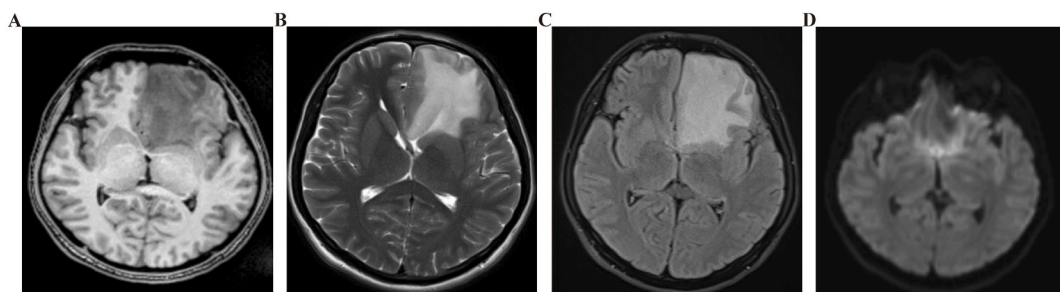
Pre-operative images of the intracranial granuloma. (A) T1-weighted MRI showed hypointense signal lesion in the left frontal lobe. (B) T2-weighted MRI demonstrated a hyperintense signal mass. (C) T2-FLAIR MRI showed the mass was hyperintense signal. (D) DWI MRI demonstrated an iso-to-hypointense signal mass.
